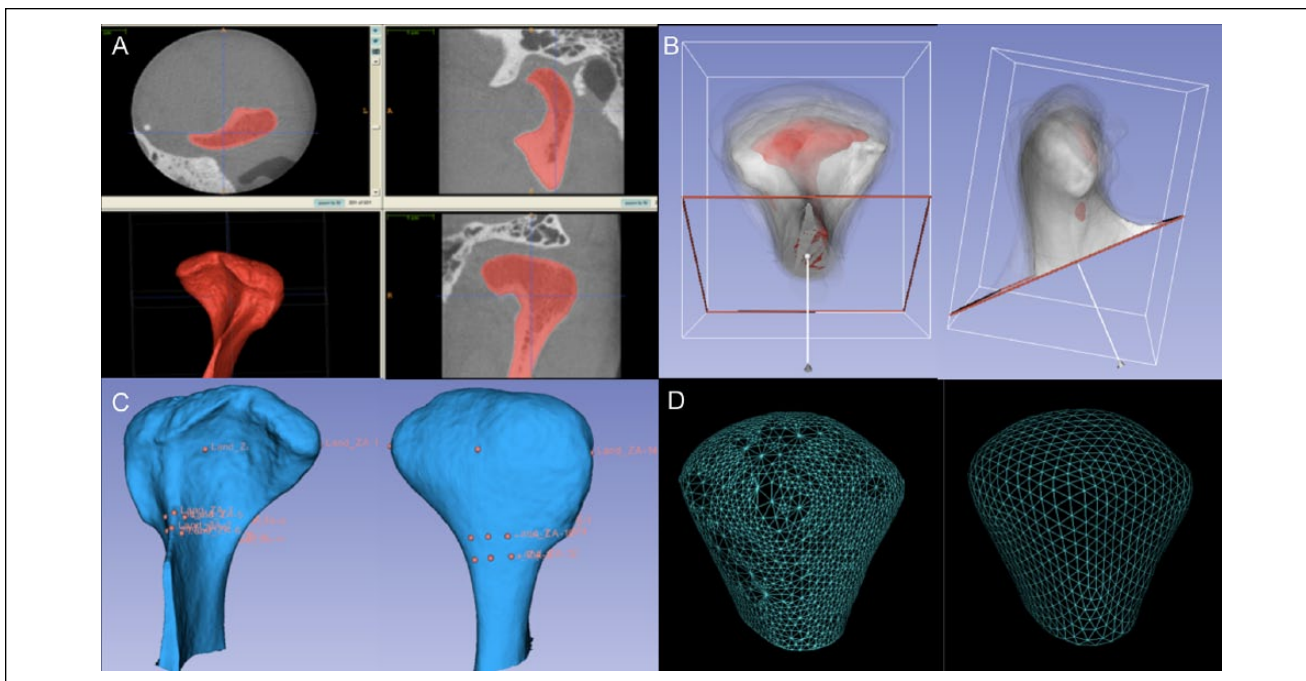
(A) Segmentation (labeling) of a participant's left condyle from the CBCT image using ITK-SNAP software. The ITK-SNAP user interface shows 3 orthogonal views (top 2 views and lower right view) of a volumetric image, linked by a common cursor (light blue crosshairs). A fourth panel (lower left view) was used to view the segmented structures in 3D. (B) The anterior and lateral views of the registered condyles. An arbitrary condyle of 1 OA subject was used as a template or reference for a common spatial orientation of all condyles. The reference condyle is shown in red, and the other TMJOA and control condyles are shown in white with 5% transparency. (C) Anterior and posterior surface model displaying the landmarks for surface registration. Sixteen landmarks were placed on the reference condyle. (D) The surface model on the left contains nonuniformly distributed triangles, and the surface model on the right established correspondence between each of the 1,002 points on the condylar surface model after spherical mapping and spherical parameterization of the input volumes run in SPHARM-PDM. CBCT, cone beam computed tomography; OA, osteoarthritis; TMJOA, temporomandibular joint osteoarthritis; 3D, three-dimensional.
